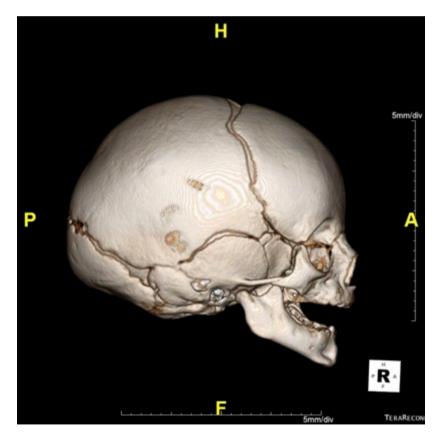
CT scan with 3D reconstruction 10 weeks since initial evaluation.
